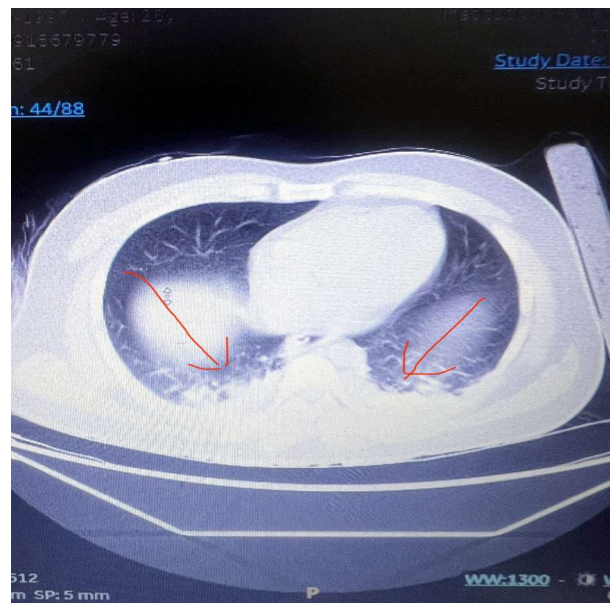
HRCT Chest showing bilateral lower lobe infiltrates consistent with aspiration pneumonia
